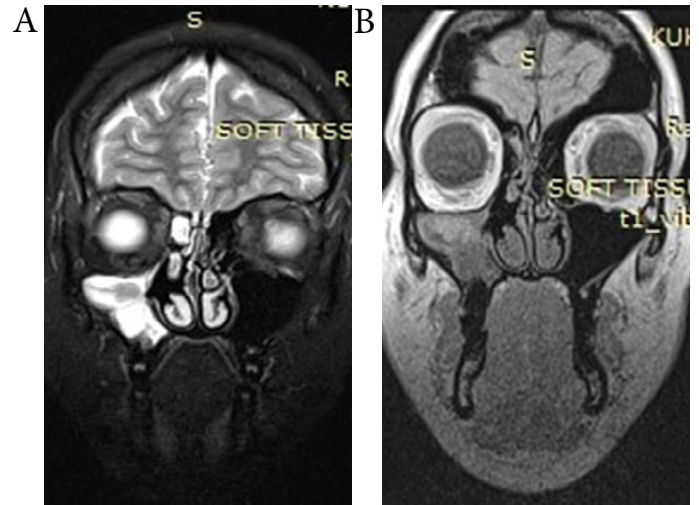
(A, B) Image of follow-up postoperative MRI in the presented case. Visible cystic lesion filling the right maxillary sinus, not penetrating the eye socket nor the nasal cavity.
